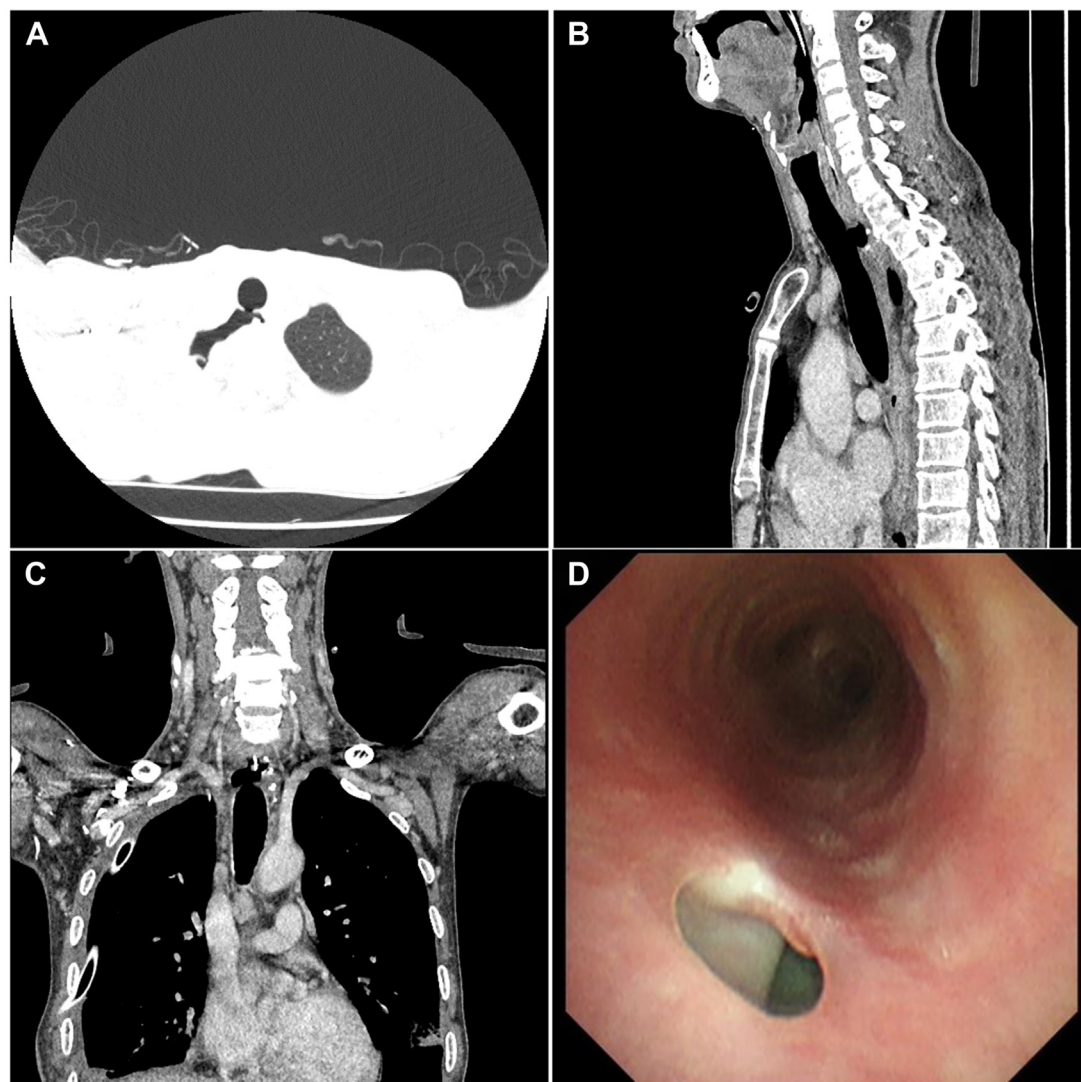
(A-C) Chest computed tomography images displaying the tracheoesophageal fistula, pleural effusion, and pneumothorax in lung window, sagittal view, and coronal view, respectively. (D) Bronchoscopy image showing the fistula located 8.5 cm from the sternum and 6 cm from the vocal cords.
